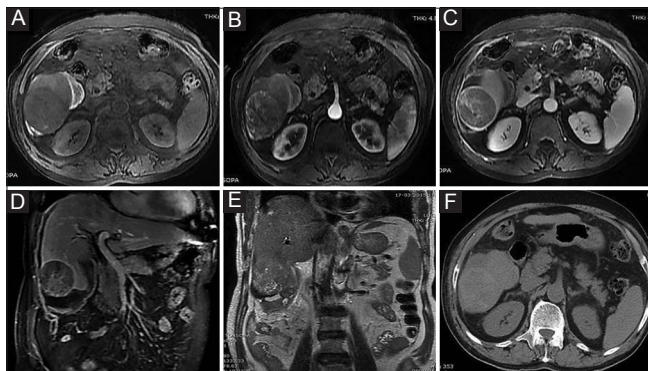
(A-F): Magnetic resonance imaging upper abdomen in unenhanced fat saturated T1W (A), axial contrast-enhanced fat saturated images in the arterial (B), and portal venous phase (C) showing a large partially exophytic well-encapsulated lesion in segment-VI of liver displaying arterial phase enhancement and washout in portal venous phase suggestive of hepatocellular carcinoma with associate T1 hyperintense perilesional fluid suggest rupture. Coronal post-contrast delayed venous phase T1W image (D) and T2W coronal image (E) shows discontinuity along the inferior capsular margin of lesion with subcapsular collection further confirm the finding. Axial non-contrast computed tomography scan image (F) at same level also shows lesion with perilesional hyperdense fluid collection
